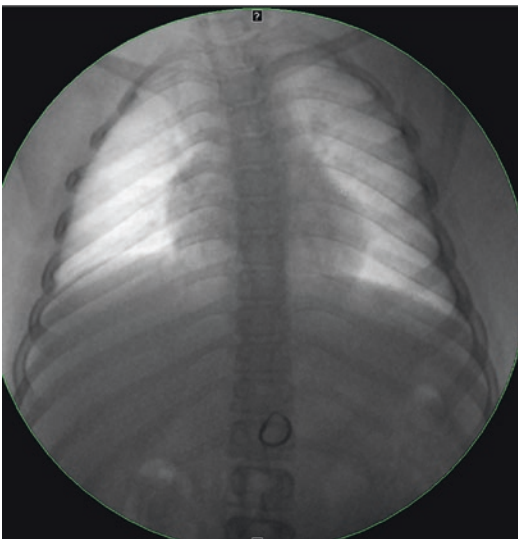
Seven-year-old girl who has swallowed her mother's earring that is easily recognized on this AP fluoroscopic view. There is no need for a plain radiograph
